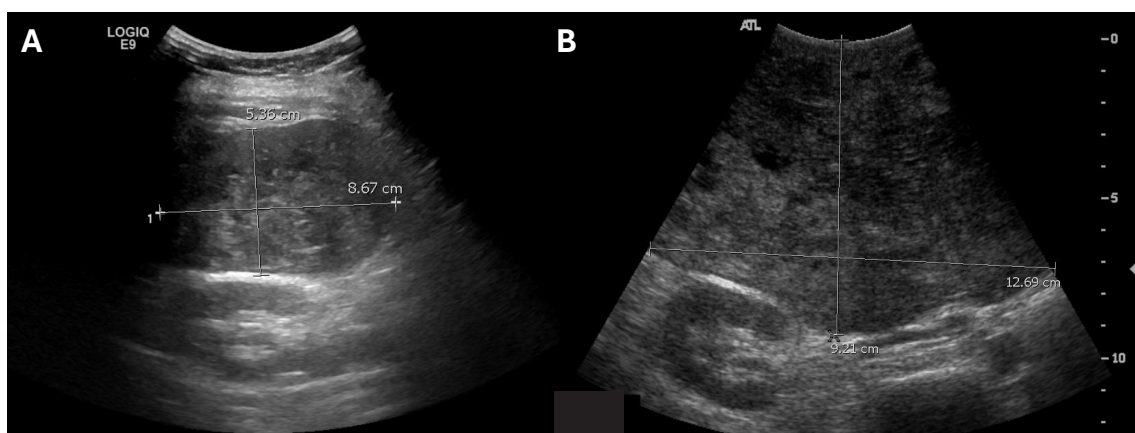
Initial (A) and intraoperative (B) ultrasound images of the large right hepatic mass. The mass is heterogenous and rapidly enlarged in the span of five months.
